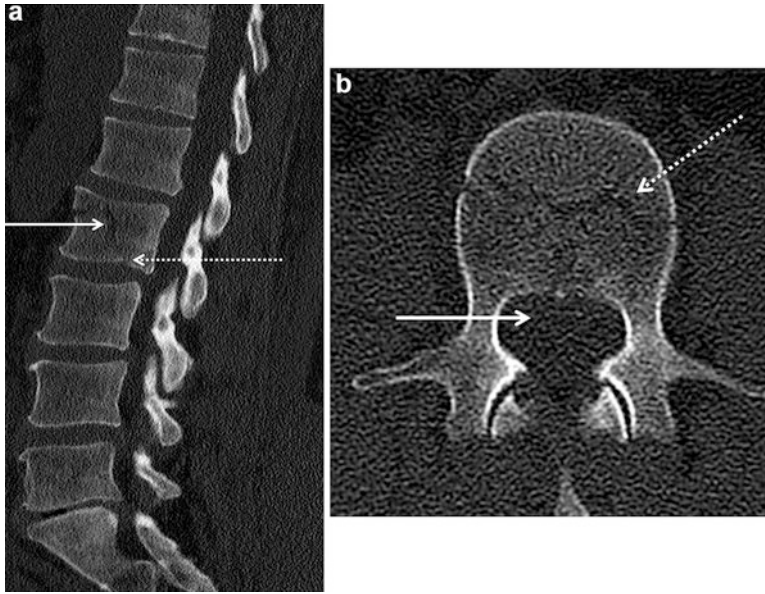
(a) Sagittal-reformatted CT image of the lumbar spine shows a minimally displaced comminuted fracture of the L2 vertebral body (*solid white arrow*) extending to the inferior endplate (*dashed white arrow*) which was occult on radiography (not shown). Compared with radiographs, CT demonstrates superior bony detailed evaluation of the cortex and trabeculae due to the lack of overlapping densities
